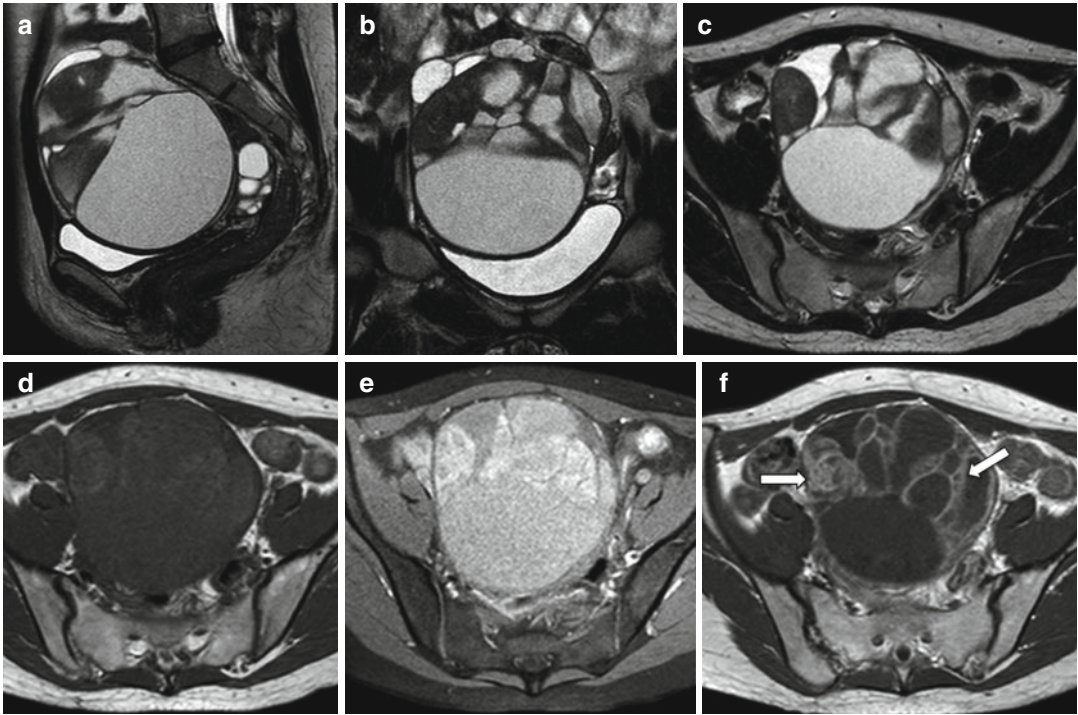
Mucinous adenocarcinoma. A 25-year-old lady with abdominal pain and elevated CA125. There is a large multiloculated, predominantly cystic pelvic mass. The locules contain variable hyperintense fluid on T2-weighted images (TR:4361, TE:80; images a–c), while others
